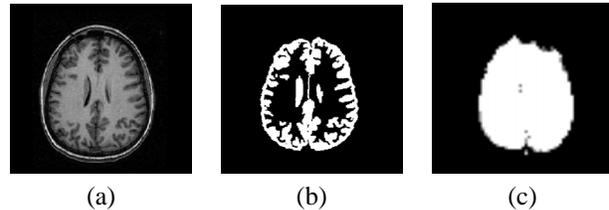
(a) Axial T₁-weighted MRI and its cortex segmentation (b). (c) Brain mask of functional images.
